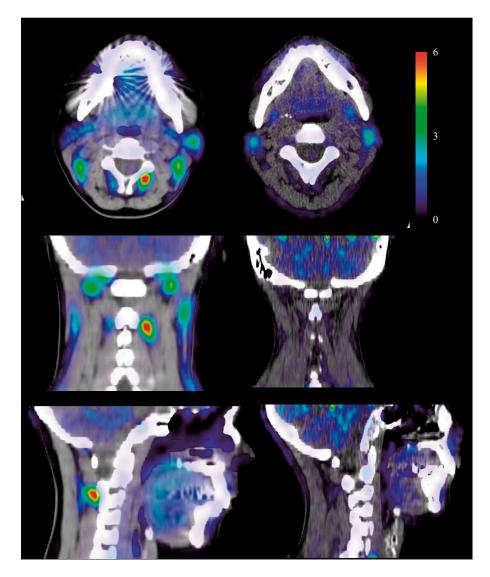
The left column displays horizontal, coronal and sagittal images of a WAD patient with presumably abnormal $[^{11}C]D$ -deprenyl uptake at the occipital bone and at the right spineous process of axis. To the right is a healthy control subject. The color scale indicates standardized uptake values. The PET image is superimposed on a CT image.
